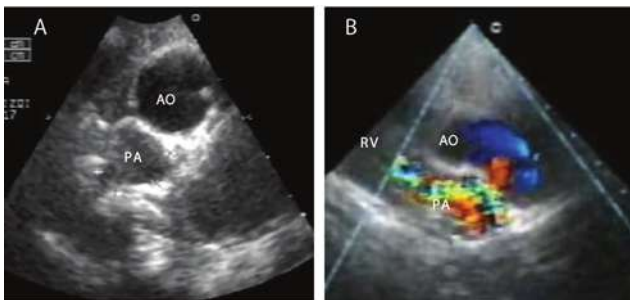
Parasternal short axis view: A. aorta left anterior to the pulmonary artery (malposition of the great arteries), B. Para-sternal long axis view : aorta anterior to pulmonary artery, turbulence in the pulmonary trunk due to pulmonary stenosis. *RV– right ventricle, PA – pulmonary artery, AO – aorta.*
